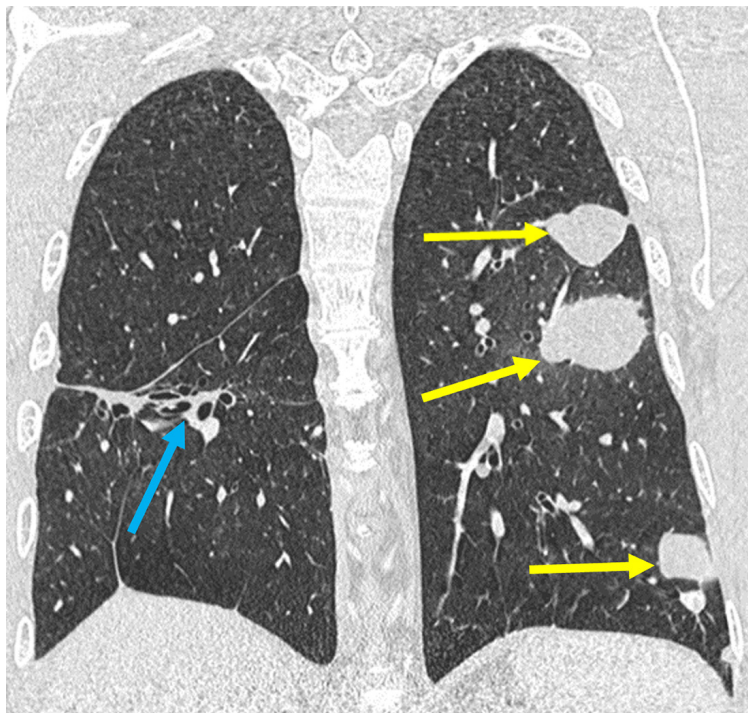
Coronal CT scan image of the chest in lung window showing nodules (yellow arrows) and associated findings in pulmonary hydatidosis, such as bronchiectasis (blue arrow).
